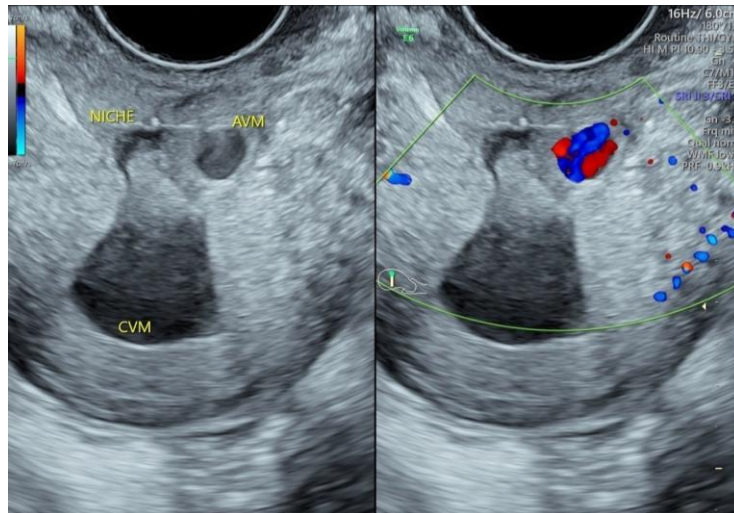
Color Doppler ultrasonography showed a hypervascularity in the uterus around the surgical lesion, suggesting a uterine arterio-venous malformation.
